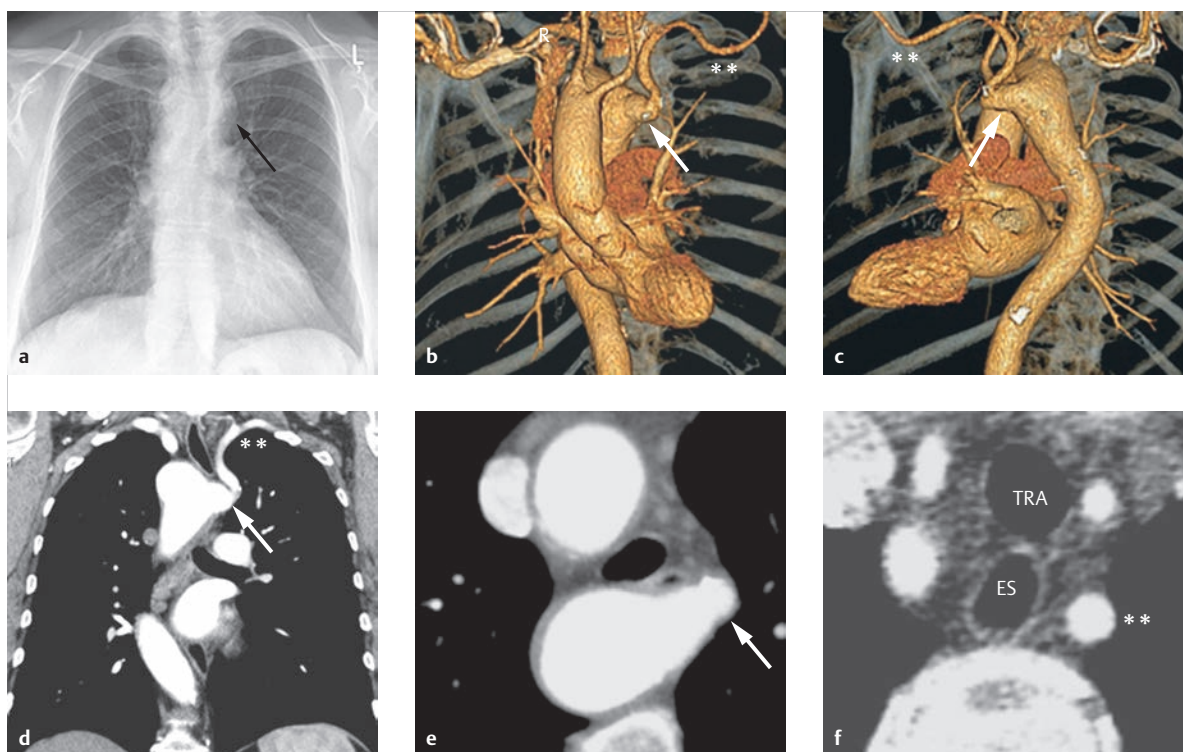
Right aortic arch with lusorian artery. Eighty-two-year-old female patient with right aortic arch and left subclavian artery (b, c, d, f, double asterisk) originating from a Kommerell diverticulum as a lusorian artery (a–e, arrows), discovered as an ancillary finding within the scope of a CT thoracic examination to clarify ambiguous pulmonary nodules.
